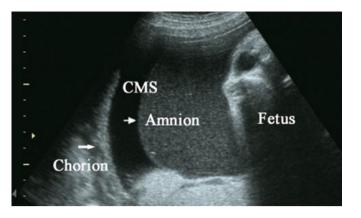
Ultrasound showing separation of the chorioamnionic membrane and polyhydramnios¹³.
